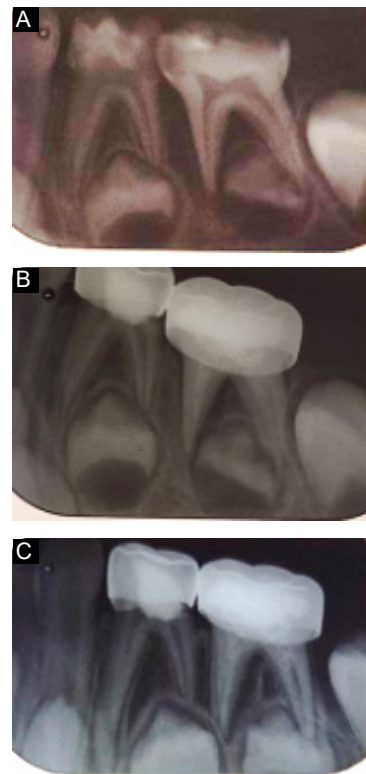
Lesion Sterilization and Tissue Repair Therapy for Primary First Mandibular Molar. A: Periapical radiography shows a large radiolucency in the furcation area and around mesial root; B,C: Radiographic examinations after 3 and 13 months show normal condition of the tooth and normal development of successor tooth. A slight remaining radiolucency around the mesial root of the teeth is detectable but the size of radiolucency is getting smaller over time and the borders of subsequent tooth's bud is intact.
